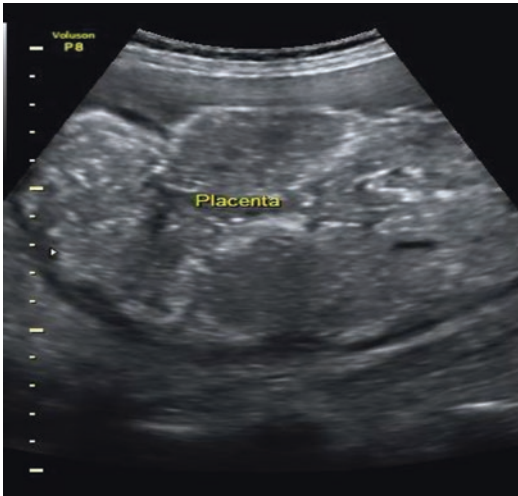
Placenta grade III in sonography in postterm pregnancy
